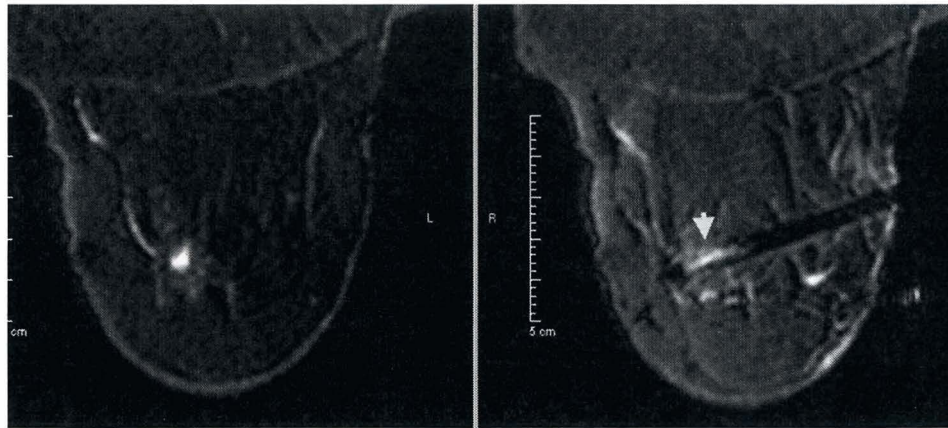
The patient in Fig. 2 was called back for second-look ultrasound and repeat mammography, but no lesion could be identified for targeted biopsy, prompting an MRI-directed biopsy. In the image on the right, the area of MRI enhancement (arrow) has dropped into the slot of the advancing needle in preparation for vacuum-assisted biopsy.
